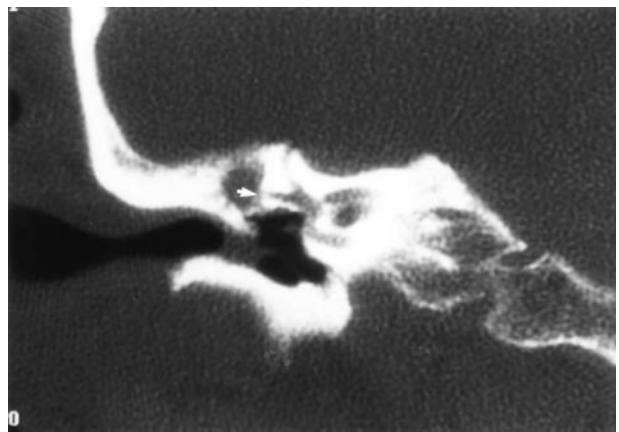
Left attic cholesteatoma, coronal computed tomographic section. The lateral wall of the attic is eroded by a soft tissue mass extending into the attic lateral to the ossicles. A polyp protrudes into the external auditory canal through a perforation of the pars flaccida of the tympanic membrane.
